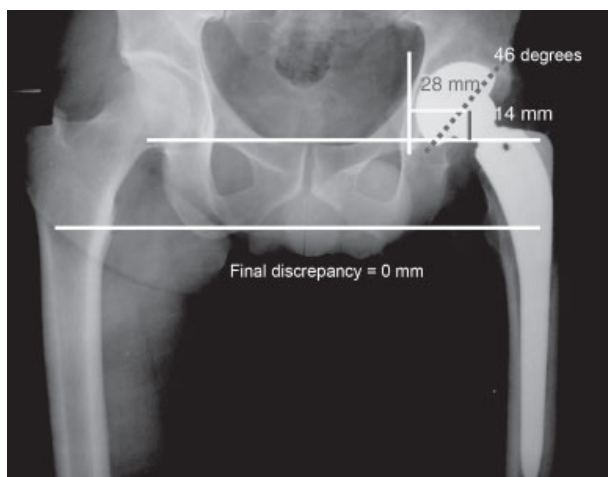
Postoperative x-ray measurements
